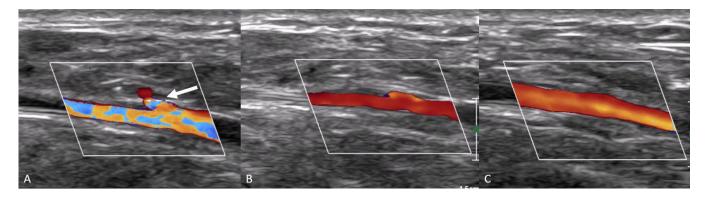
(A) Extravascular ultrasound (EVUS) assessment of the tibial artery after sheath removal using color doppler to identify the location of the arteriotomy. (B) EVUS-guided pressure is held while maintaining patency of the artery. (C) Evaluation of the tibial artery post pressure confirming successful EVUS-guided patent hemostasis.
